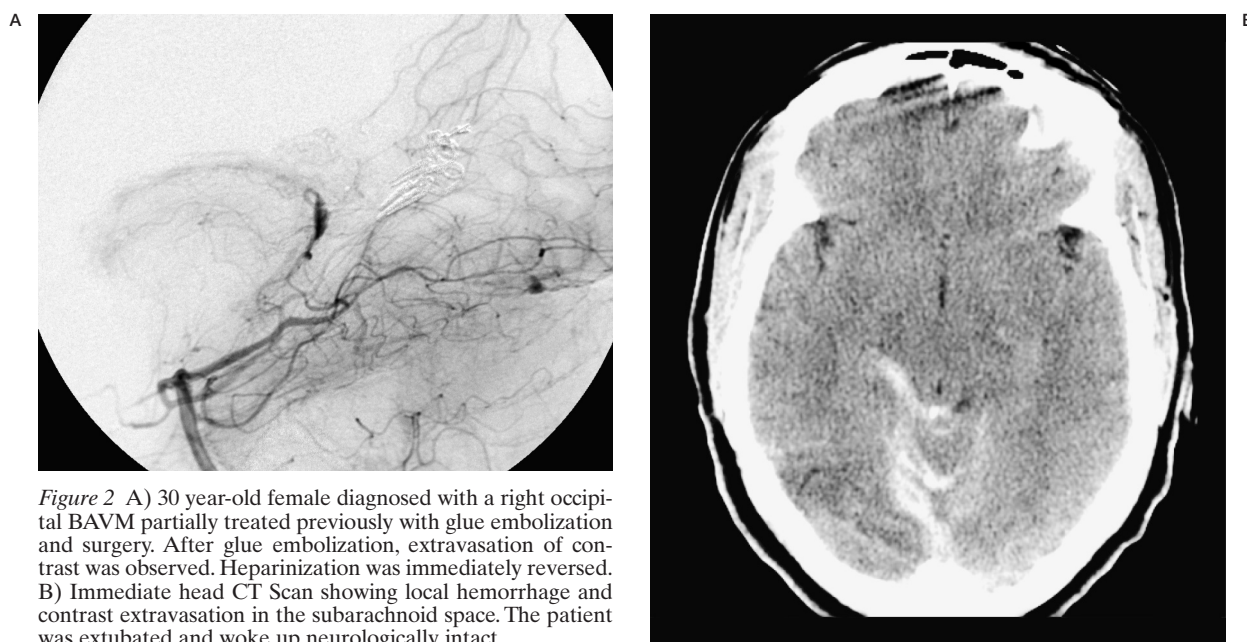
A) 30 year-old female diagnosed with a right occipital BAVM partially treated previously with glue embolization and surgery. After glue embolization, extravasation of contrast was observed. Heparinization was immediately reversed. B) Immediate head CT Scan showing local hemorrhage and contrast extravasation in the subarachnoid space. The patient was extubated and woke up neurologically intact.
